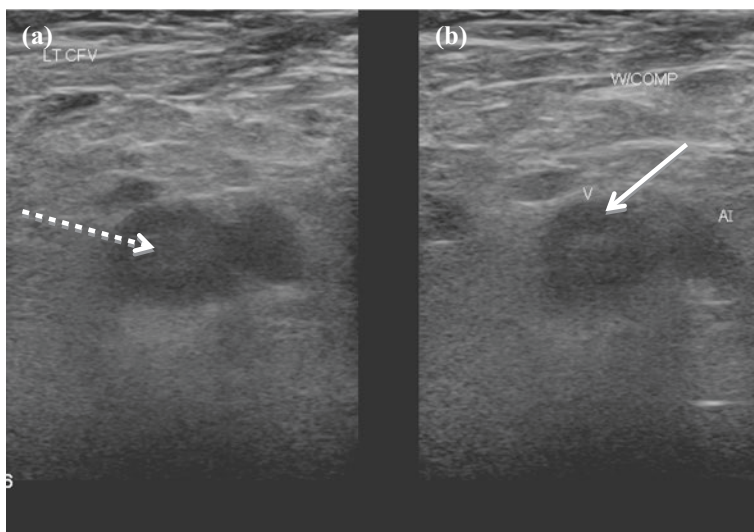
Ultrasound of the left common femoral vein in a patient presenting with a swollen, painful left leg. Image a shows echogenic material within the vessel, consistent with acute thrombosis, denoted by the broken arrow. Image b demonstrates non-compressibility of the vessel, denoted by the white arrow. Both findings are consistent with acute DVT
